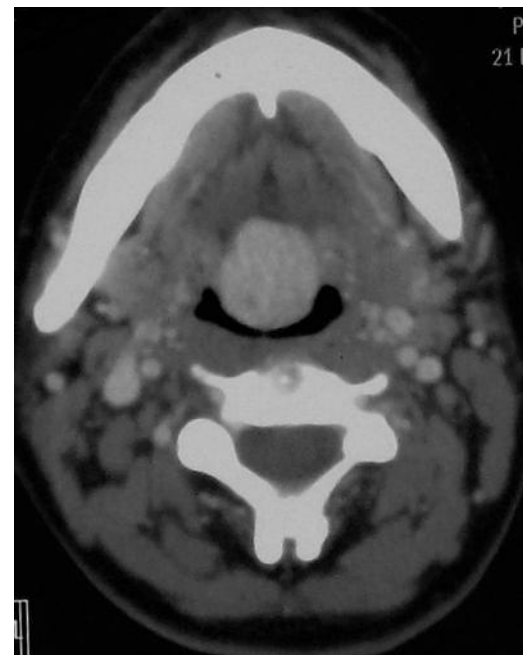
CT scan of the 36-year-old woman showed an enhanced clear-cut mass with a uniform dense in an axial view.
